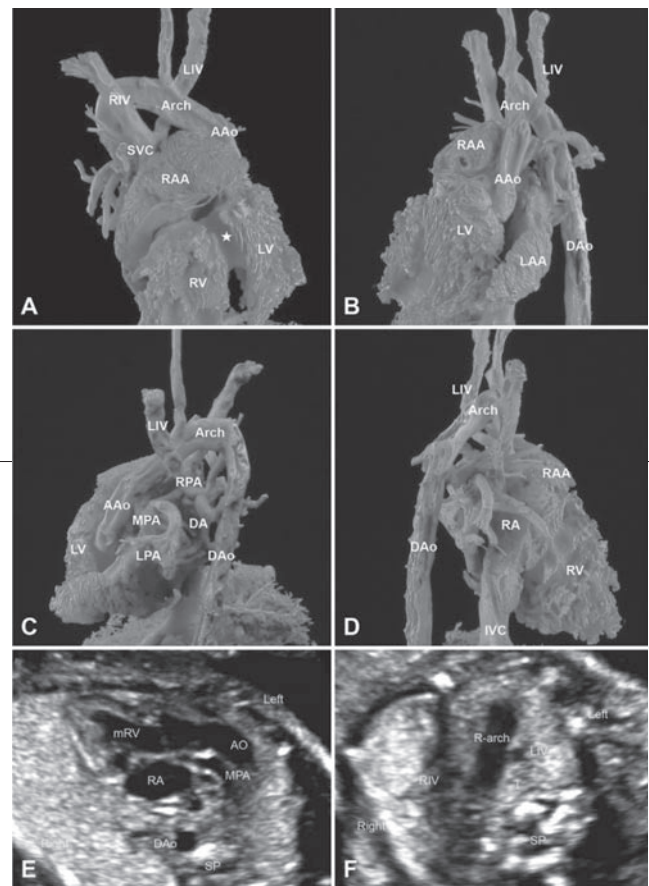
Cast demonstration of a fetus with VSD, right aortic arch, subaortic LIV, anomalous DA connection, etc. (Case 2). (A) Anterior view: An abnormal connection between ventricles indicates the existence of a large ventricular septal defect (white asterisk). Subaortic LIV is detected coursing anomalously under the aortic arch. (B) Left side view: Ascending aorta (AAo) is originated from the left lateral border of LV. (C) Left posterior 45° view: DA anomalously connects DAo and RPA. (D) Right side view: Aortic arch abnormally coursed from left-anterior to right-posterior, confirming a right aortic arch. (E) Prenatal echocardiography showed dextroversion of the heart, AO and MPA both originated from mRV, pulmonary valvular atresia and PA stenosis. (F) Aortic arch located on the right side of trachea and subaortic LIV was mistakenly identified as LSVC in the prenatal sonography.
